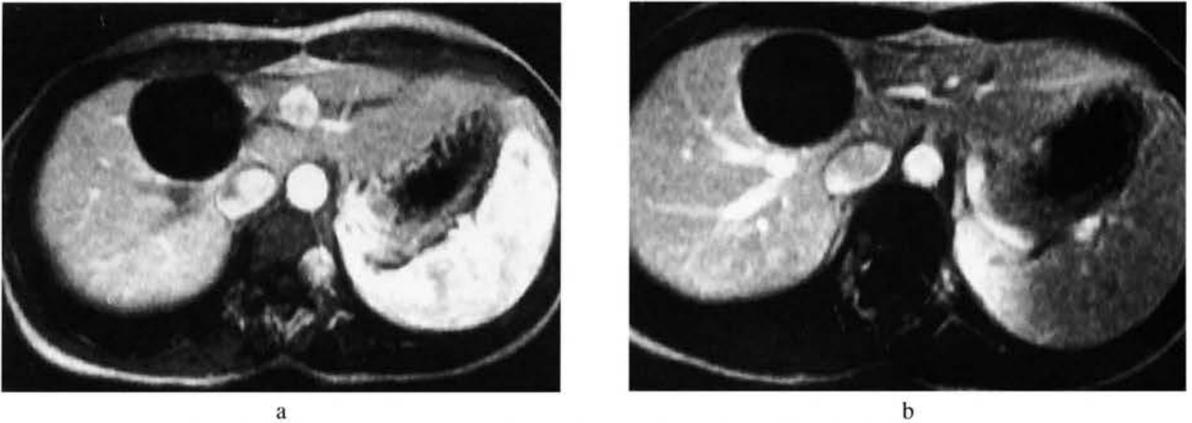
Liver Cysts. Immediate (a) and 5 minute (b) post gadolinium spoiled gradient echo MR images demonstrate a well defined 6 cm lesion that is signal void on early (a) and later (b) post gadolinium images diagnostic for a liver cyst.
